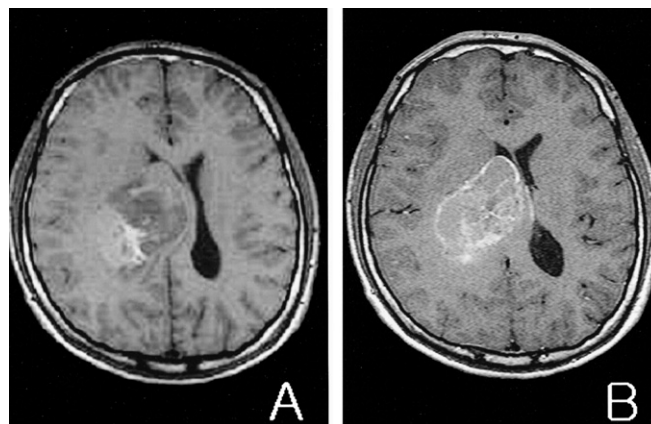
T1-weighted axial MRIs. (A) A 6×4 cm mass in the right thalamic area can be seen, which compressed the right lateral ventricle. (B) Gadolinium produces inhomogeneous, ring-like enhancement.
